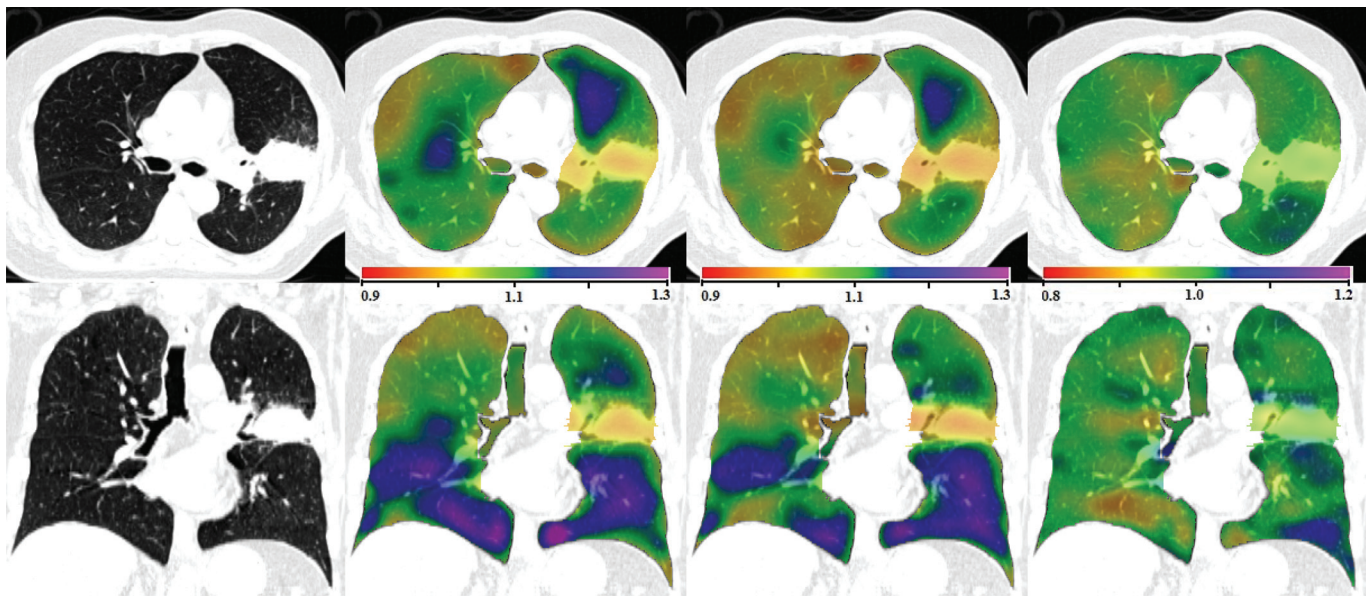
Transverse (top) and coronal (bottom) views of (left to right) the original CT, JAC_{T_1} , $JAC_{T_2} \circ T_0$, and JAC_{RATIO} for human subject H-2. Note the color scales for JAC_{T_1} and $JAC_{T_2} \circ T_0$ are 0.9 to 1.3, and for JAC_{RATIO} the scale is 0.8 to 1.2.
